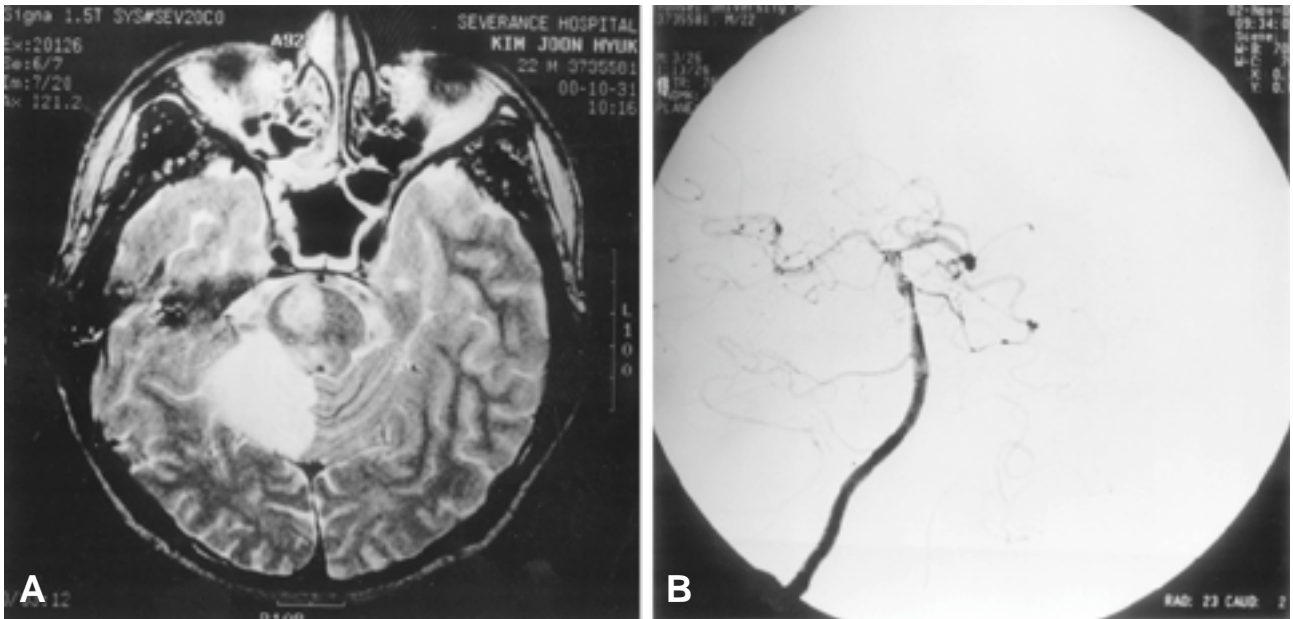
(A) T2 weighted brain MRI shows acute infarction of the right pons and cerebellum. (B) Vertebral angiography (oblique view) shows irregular stenosis and intimal flap of the basilar artery.
